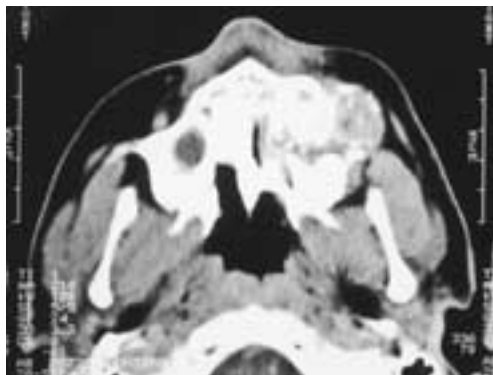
CT scan of infantile myofibromatosis lesion in left maxilla before surgery.
